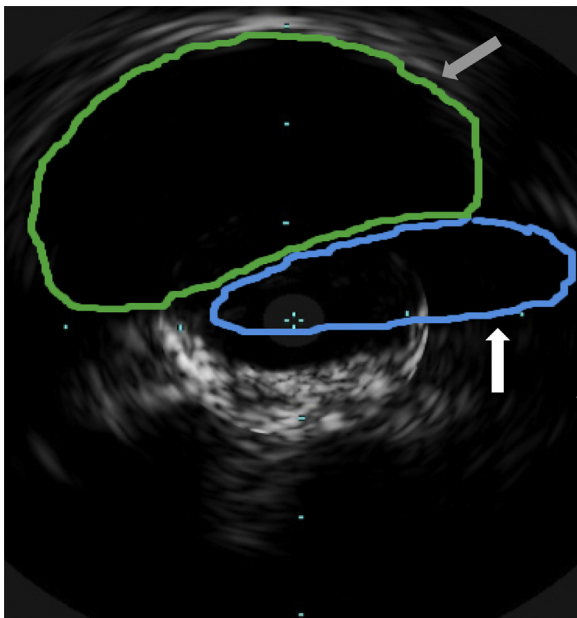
Intravascular ultrasound demonstrating flattened left renal vein (LRV; *white arrow*) lying posterior to the abdominal aorta (*gray arrow*).
